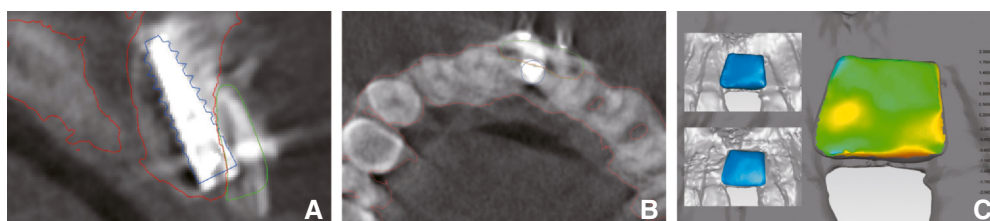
Immediate postoperative assessment. A, B, Superimposition of preoperative ridge contour (red), planned implant (blue), and virtual bone graft (green) onto immediate postoperative cone beam computed tomography imaging. C, Immediate postoperative graft contour accuracy. Left: comparison between designed graft and graft placed clinically (blue). Right: chromatic deviation map.
